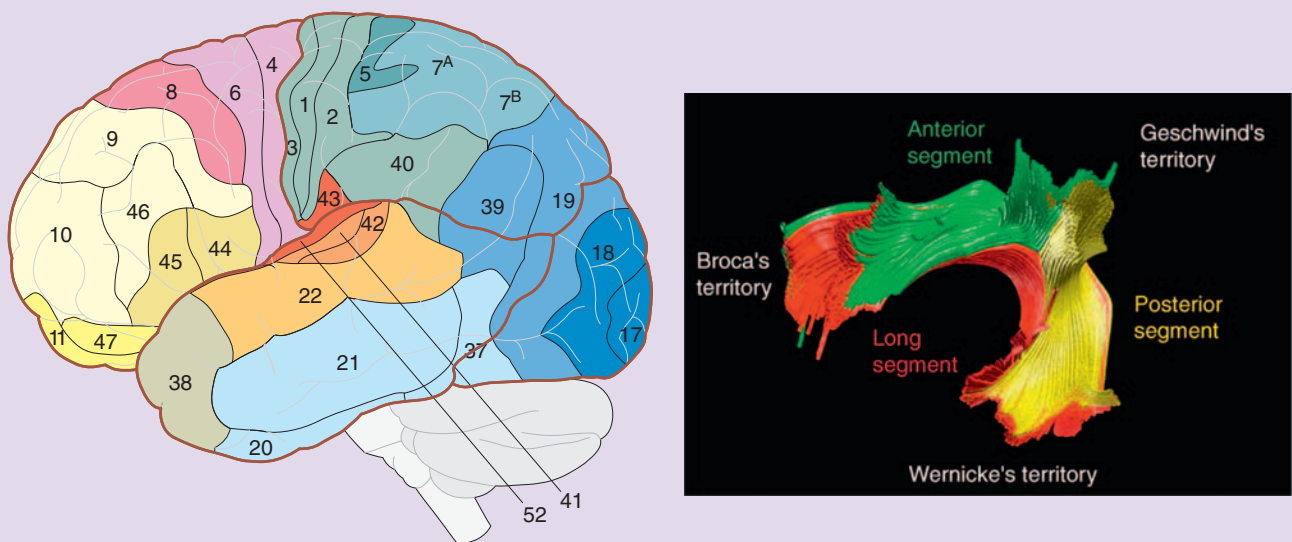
Right panel shows the fiber tracts that connect the functional language areas of Wernicke’s area in the temporal lobe and Broca’s area in the frontal lobe in the left hemisphere. These tracts are reconstructed using tractography and MRI images. A direct pathway between Broca’s and Wernicke’s areas, shown in red, corresponds to the classical description of the arcuate fasciculus that has been long thought to be the major connective ‘highway’ between these important language areas. They also found an indirect pathway: the anterior segment connects Broca’s area with a region in the inferior parietal lobe known as Geschwind’s territory (shown in green) and a posterior segment that connects Geschwind’s territory and Wernicke’s area (shown in yellow). Left panel shows where these tracts are relative to the anatomical structures of the left hemisphere. *Source:* Adapted, with permission, from Catani *et al.*, 2005.
